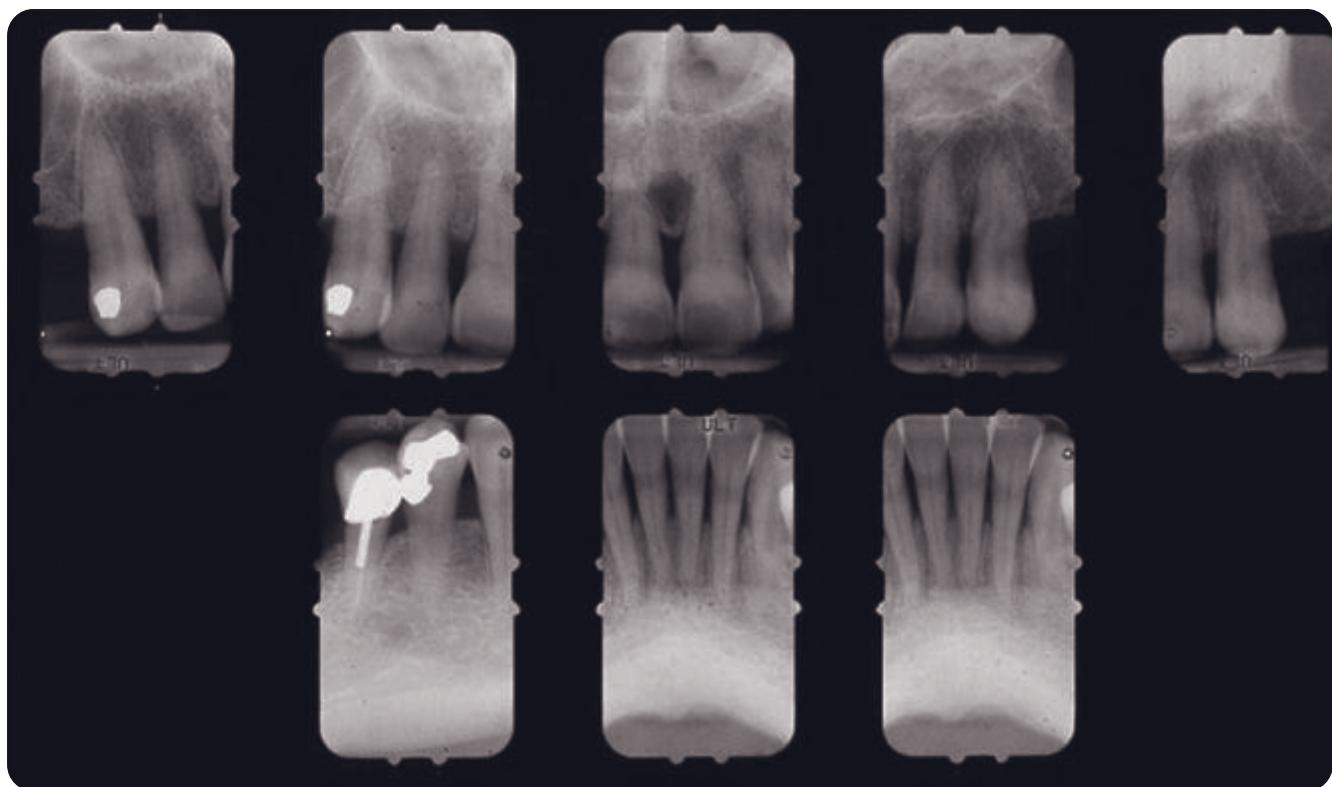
Preoperative anterior radiographs. The periodontium, although reduced, is maintainably healthy. There is generalized grade 1 mobility.
